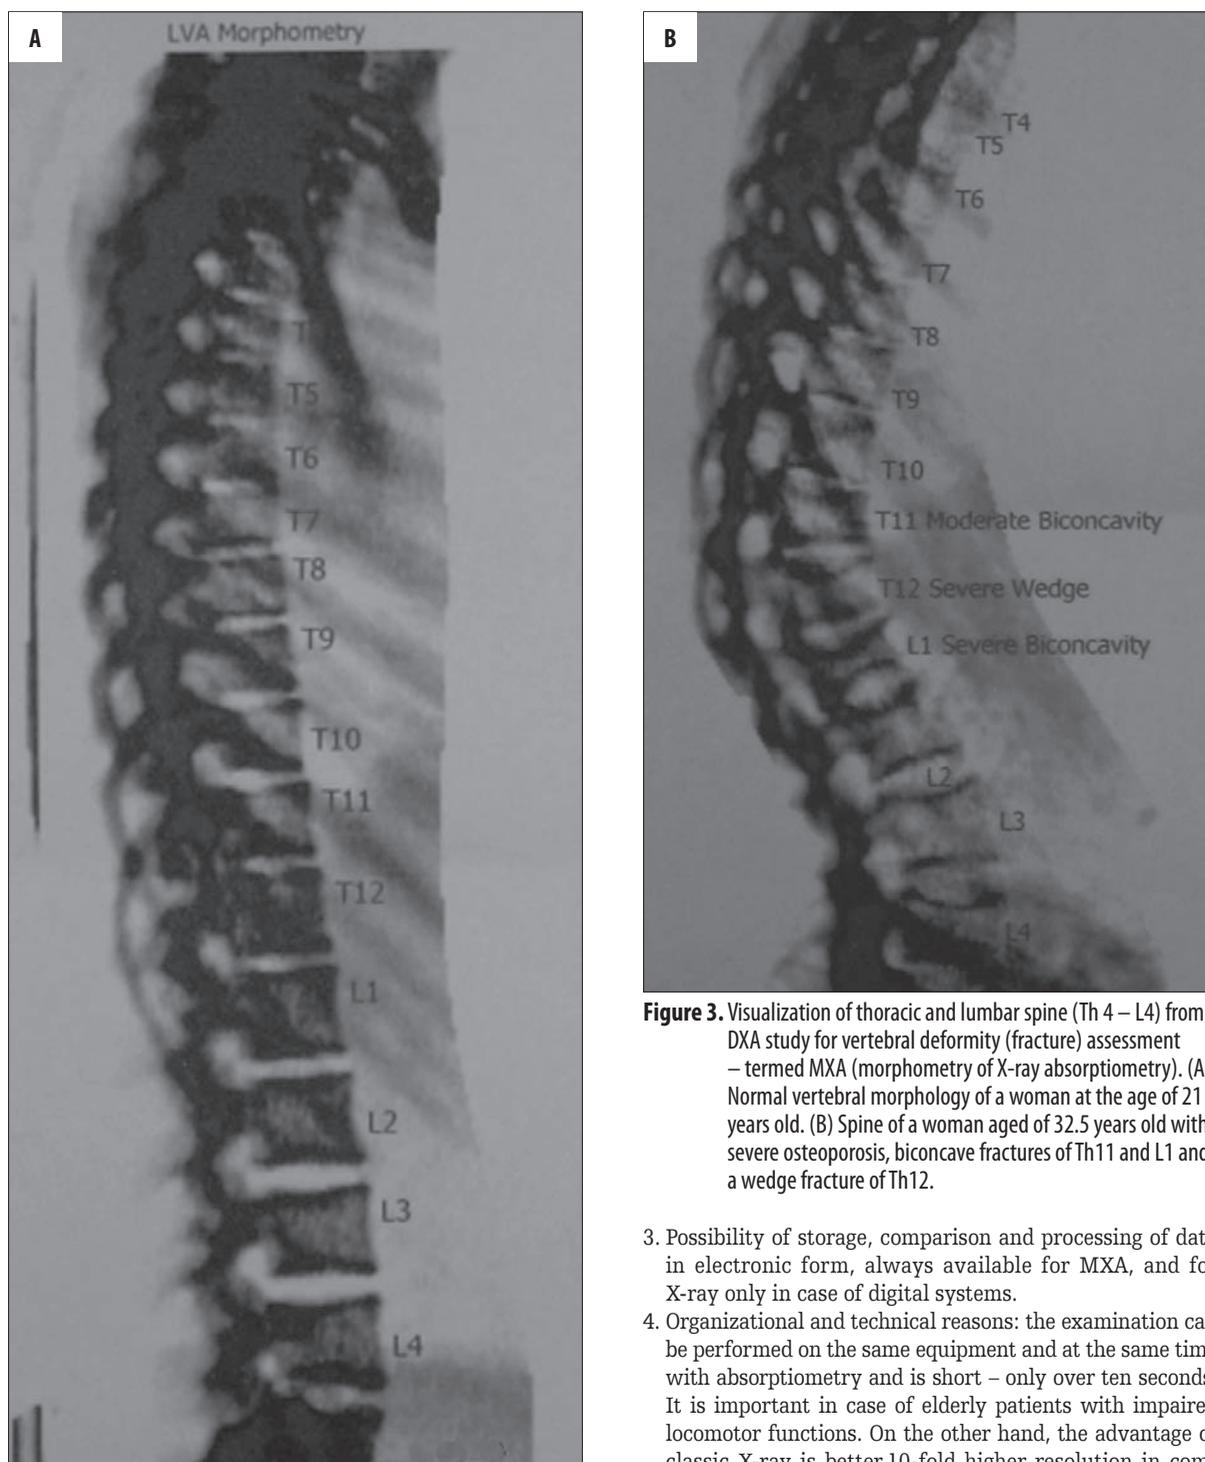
Visualization of thoracic and lumbar spine (Th 4 – L4) from DXA study for vertebral deformity (fracture) assessment – termed MXA (morphometry of X-ray absorptiometry). (A) Normal vertebral morphology of a woman at the age of 21 years old. (B) Spine of a woman aged of 32.5 years old with severe osteoporosis, biconcave fractures of Th11 and L1 and a wedge fracture of Th12.
